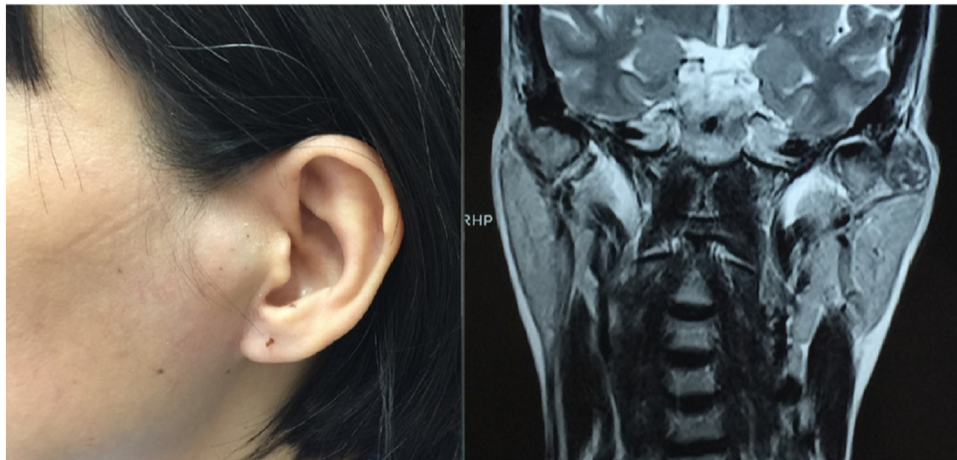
A mass in the left pre-auricular region in clinical exam and MRI.
